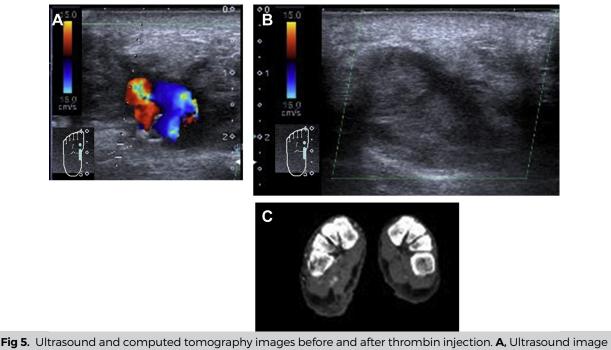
Ultrasound and computed tomography images before and after thrombin injection. A, Ultrasound image before thrombin injection. The pseudoaneurysm reportedly decreased in size compared with the size before embolization of main feeder. B, Ultrasound image just after thrombin injection. The pseudoaneurysm was completely thrombosed. C, Computed tomography image conducted 1 month after the treatment. The pseudoaneurysm disappeared completely.
